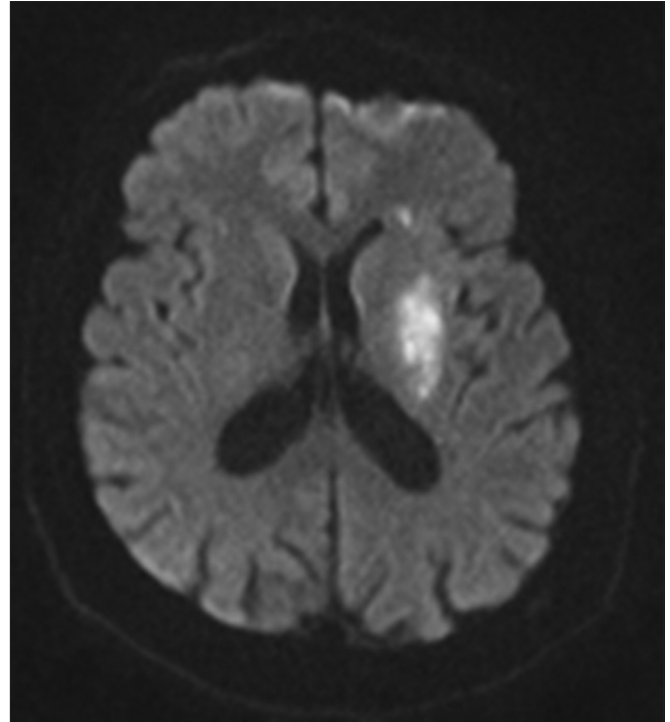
A 74-year-old woman with acute stroke. DW MR image shows asymmetrical restricted diffusion in the left lentiform nucleus.
